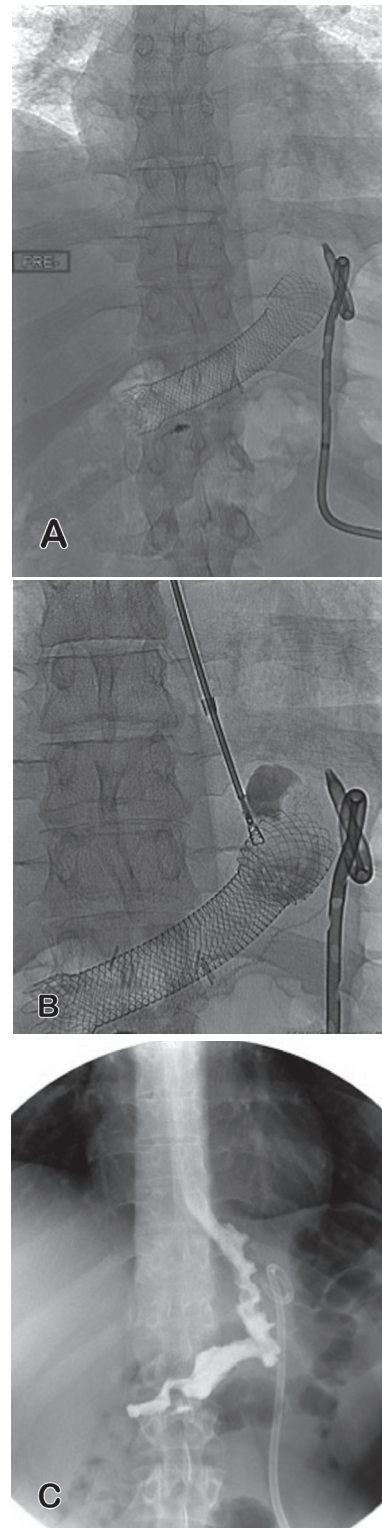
Control radiograph showing A) migrating esophageal stent into the gastric lumen. B) Intra procedural radiograph with a forceps capturing the proximal edge of the stent. C) Post removal esophagogram with no residual leak.
